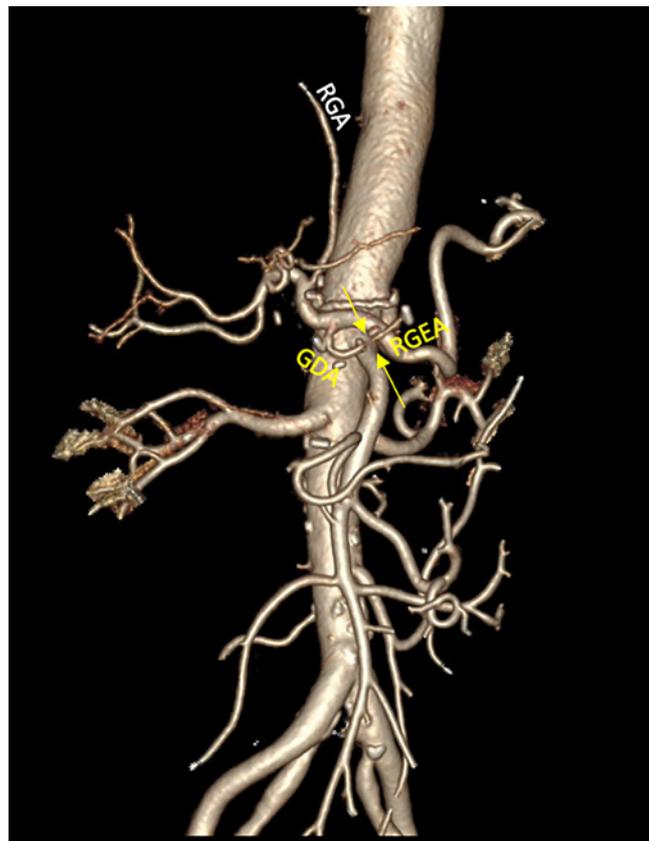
Postoperative CT scan with three-dimensional reconstruction. Yellow arrow: anastomosis site. RGA, right gastric artery; RGEA, right gastroepiploic artery; GDA, gastroduodenal artery.
